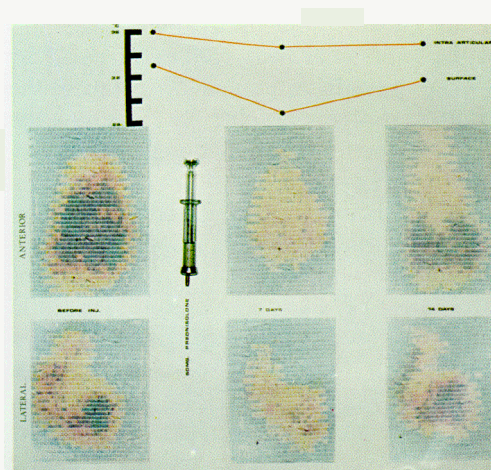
Technetium scintigrams, anterior and lateral, of knee joint in a patient with rheumatoid arthritis. The acutely inflamed, highly vascular synovium produces intense localization of the isotope (left). 50 mg of prednisone was injected intra-articularly, with marked reduction of inflammation and vascularity 7 days later, and a return of inflammation at 14 days. The associated fall and later rise of skin temperature, measured by radiometer is shown above, with the corresponding, much slighter, fall in intra articular temperature measured by thermistor.
